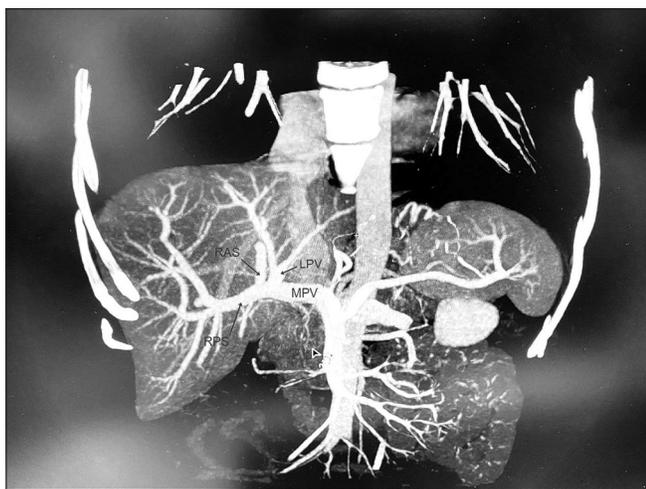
CT imaging of Portal vein anatomical anomaly. MPV, main portal vein; LPV, left portal vein; RAS, right anterior sectoral branch; RPS, right posterior sectoral branch
